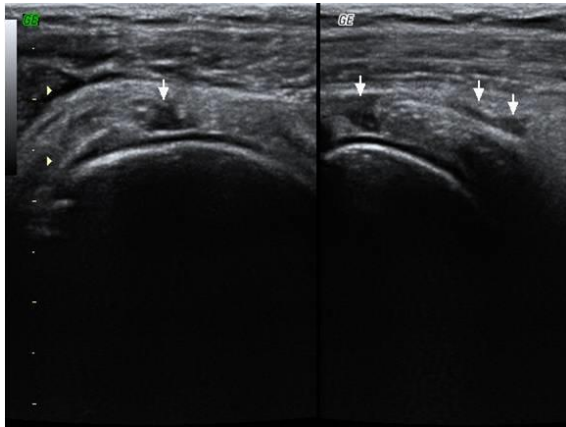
ultrasonography of FTT
